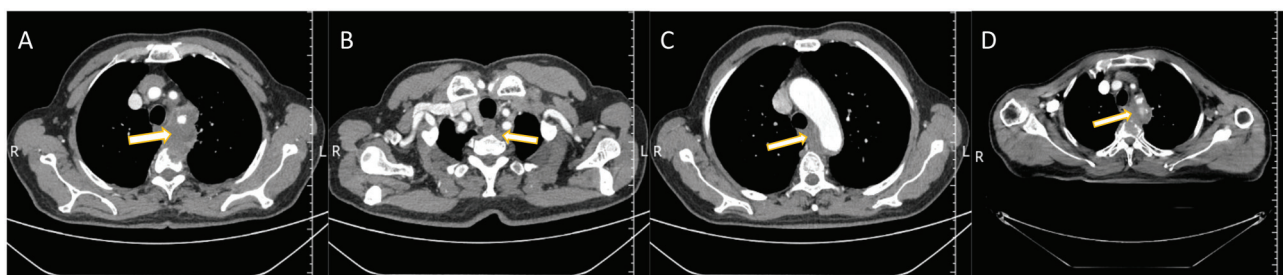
Chest computed tomography scans of a 70-year-old male patient. (A) The largest cross-section of the mediastinal mass (arrow). (B) The upper border of the mediastinal mass (arrow). (C) The lower border of the mediastinal mass (arrow). (D) Reduced mediastinal mass (arrow) after radiotherapy.
